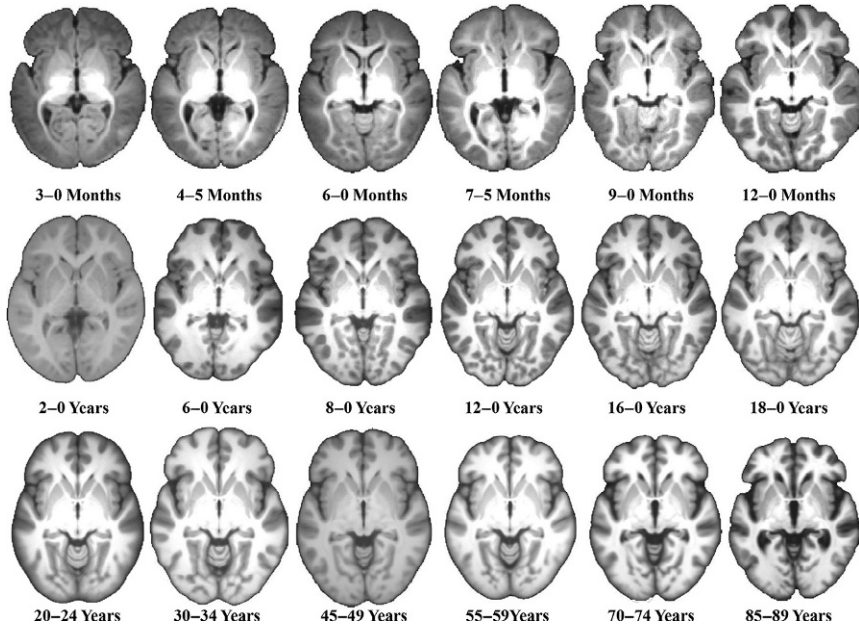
Brain average MRI templates for selected ages from the Neurodevelopmental MRI Database. This is an axial slice at the level of the anterior commissure. The 2–0 years template is based entirely on 1.5T MRI volumes, the mid- to late-adults are based primarily on 1.5T MRI volumes, and the rest are based on 3T volumes. The brains from different ages are shown as the same size, though they differ in size for the templates (cf., Figure 2).
